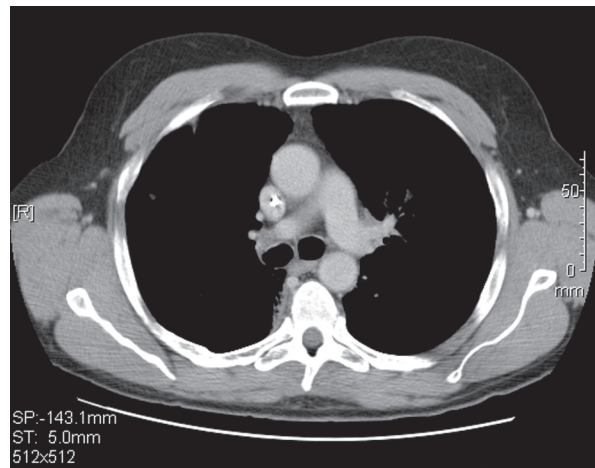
CT scan of the chest showing response to the combination of gemcitabine and irinotecan.
